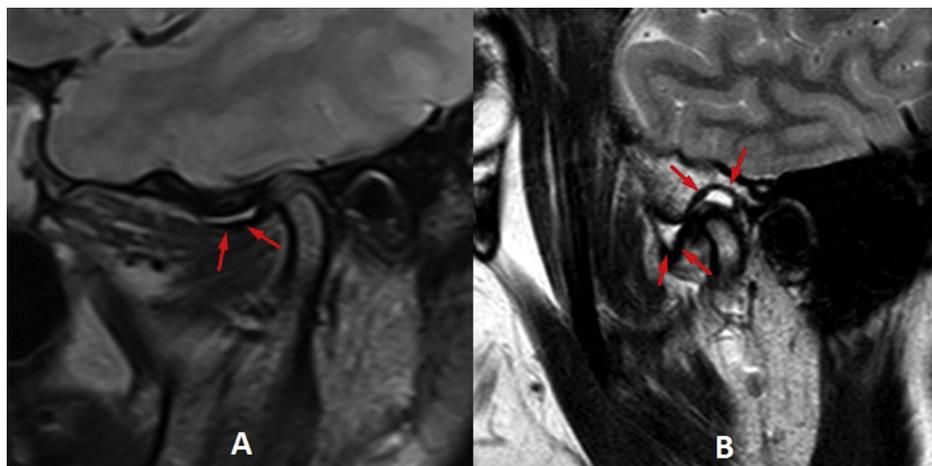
A) TMJ moderate effusion (1) is seen on MRI B) TMJ marked effusion (2) is seen on MRI.
